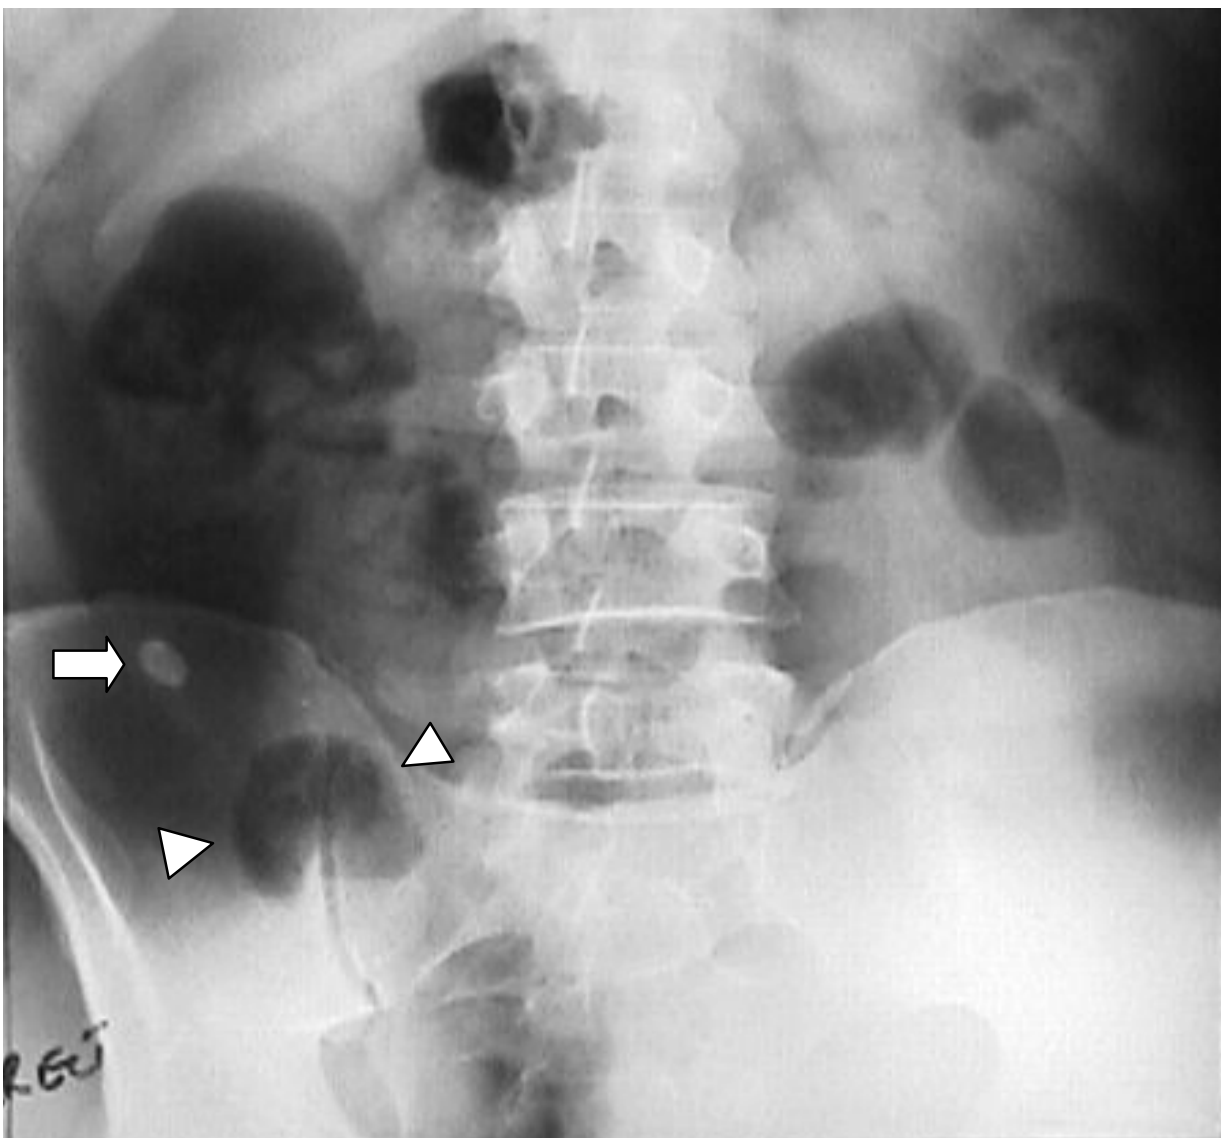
Plain abdominal radiograph demonstrating the presence of an appendicolith (arrow) and a sentinel loop (arrowheads) in the right lower quadrant.
